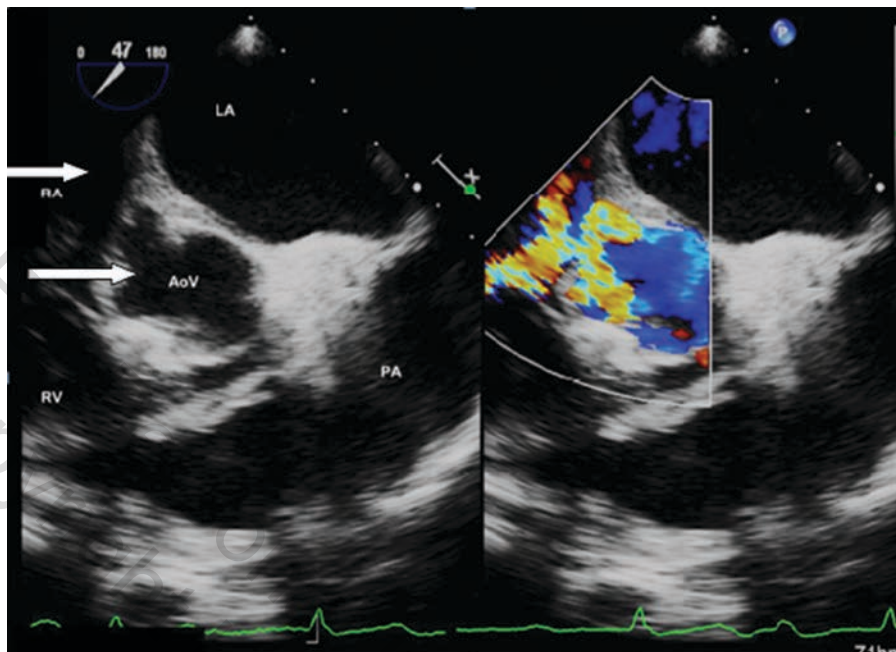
Left: Aorta to right atrium (RA). Arrows pointing at RA and aortic valve (AoV). Right: Doppler showing flow from aorta to RA.
